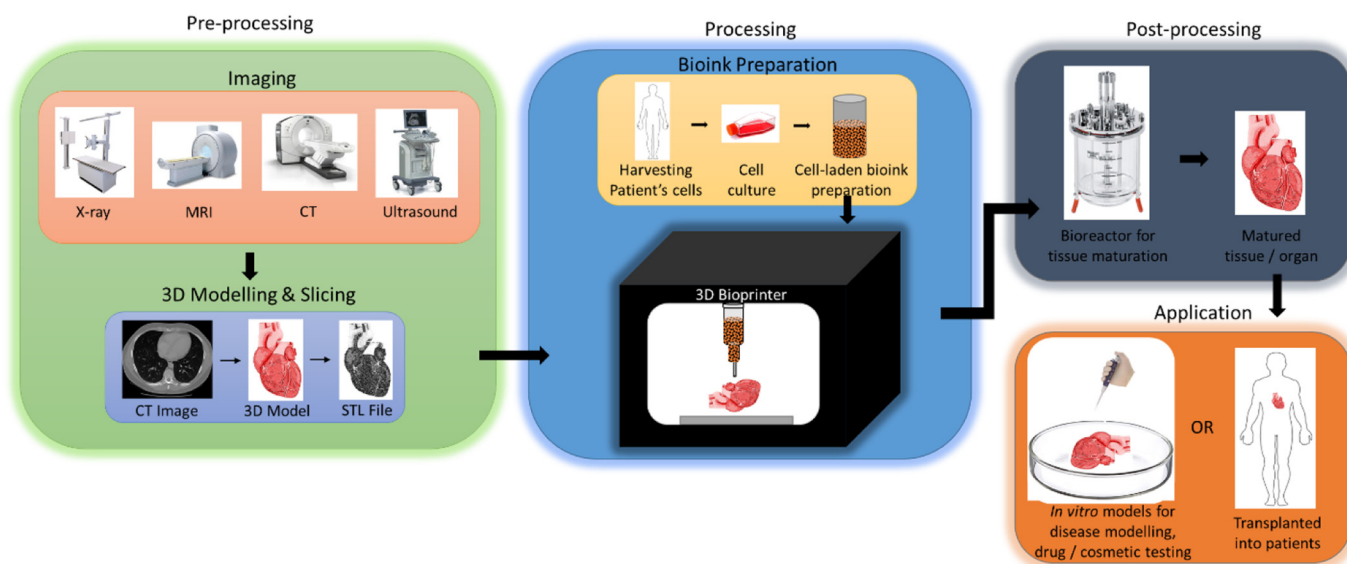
A typical bioprinting process flow consisting of three steps namely pre-processing (Medical imaging using X-ray, MRI, CT or Ultrasound, 3D modelling, and slicing; preparation of cell-laden bioink) (Image courtesy: www.southernstatesimaging.com, www.istockphoto.com, www.3gehealthcare.com), processing (actual bioprinting process), and post-processing (tissue maturation in a bioreactor) (Image courtesy: www.broadleyjames.com).
